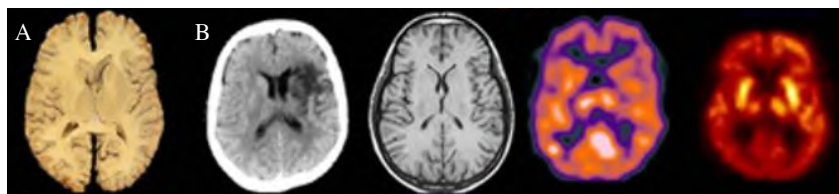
Examples of different imaging modalities: (A) Real axial slice of the human brain; (B) axial slice of the human brain acquired with different imaging modalities from left to right: X-ray, MRI, SPECT and PET. (Figure modified from <http://www.unige.ch/cyberdocuments/>).
